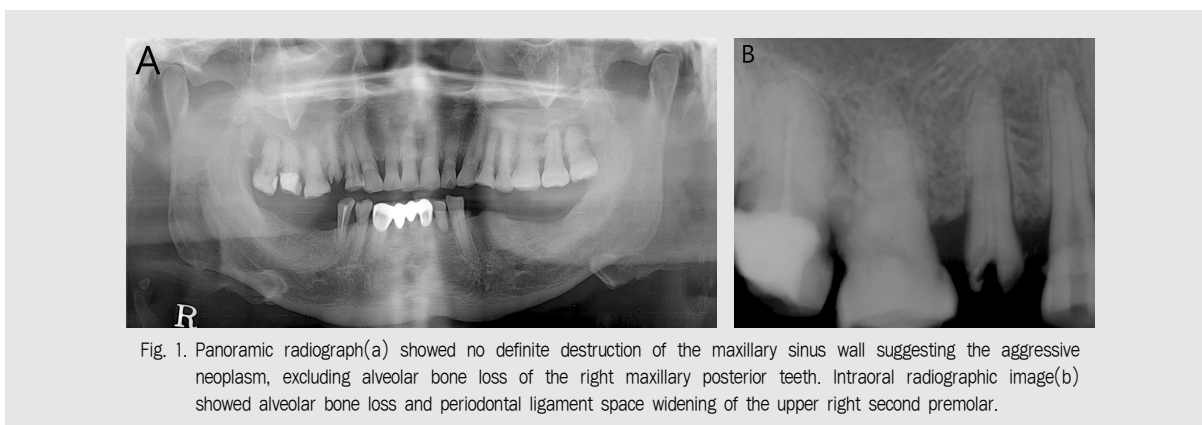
Panoramic radiograph(a) showed no definite destruction of the maxillary sinus wall suggesting the aggressive neoplasm, excluding alveolar bone loss of the right maxillary posterior teeth. Intraoral radiographic image(b) showed alveolar bone loss and periodontal ligament space widening of the upper right second premolar.
